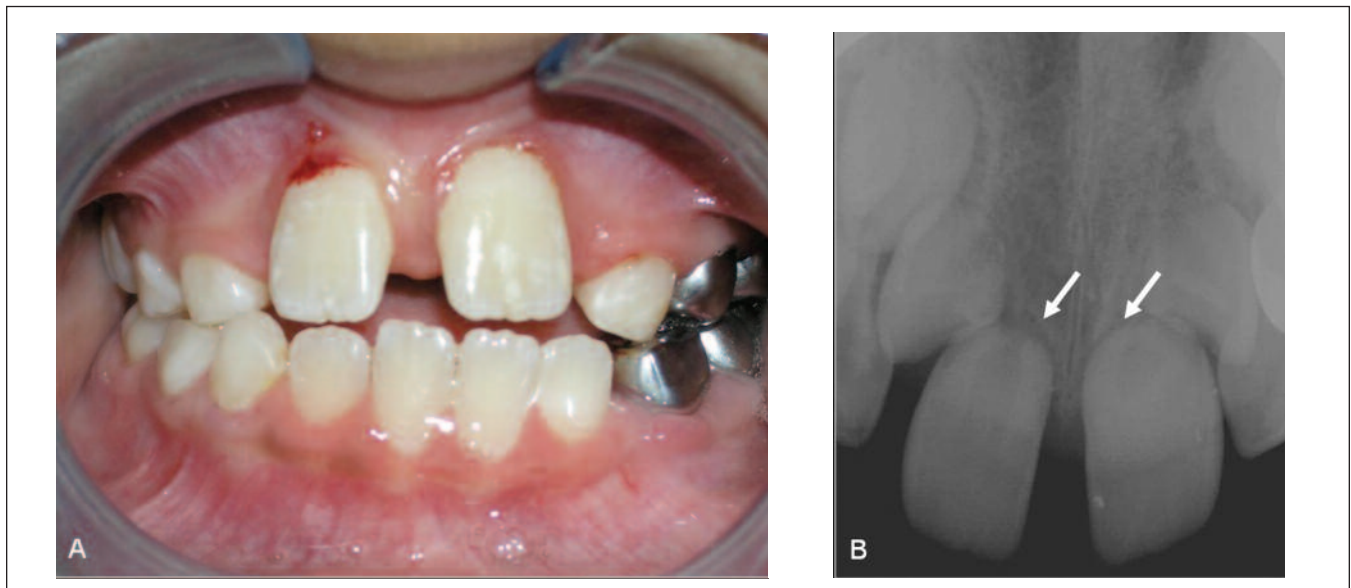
(A) Intraoral photo demonstrating splaying of incisor teeth, and (B) a periapical radiograph revealing root agenesis on incisor teeth resulting in delayed eruption.
